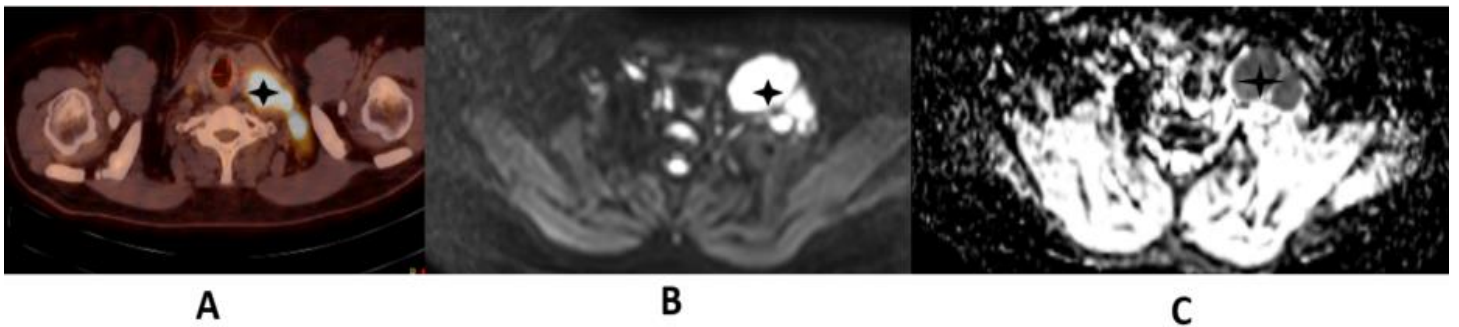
37 years old male, a case of Non-Hodgkin lymphoma, different views for the supraclavicular lymphoma (black star)  $\text{SUV}_{\text{max}}=14.77$ ,  $\text{ADC} = 0.54 \times 10^{-3} \text{ mm}^2/\text{s}$  on PET (image A),  $\text{DWI } b=800 \text{ s/mm}^{-2}$  (image B) and ADC mapping (image C).
